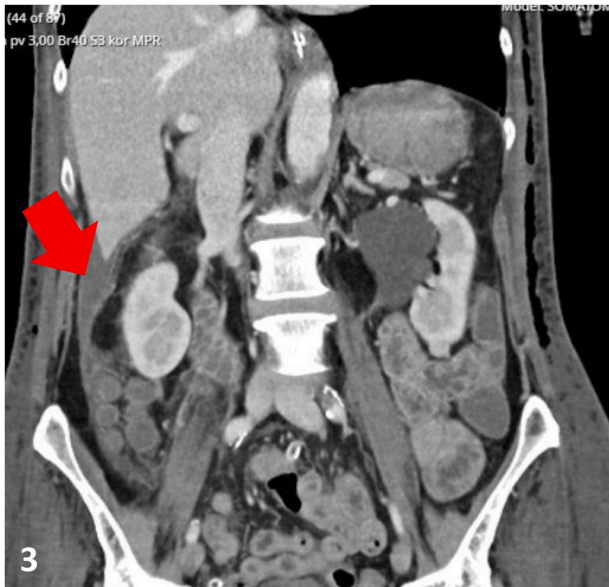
CT scan showing a subhepatic collection (arrow).
